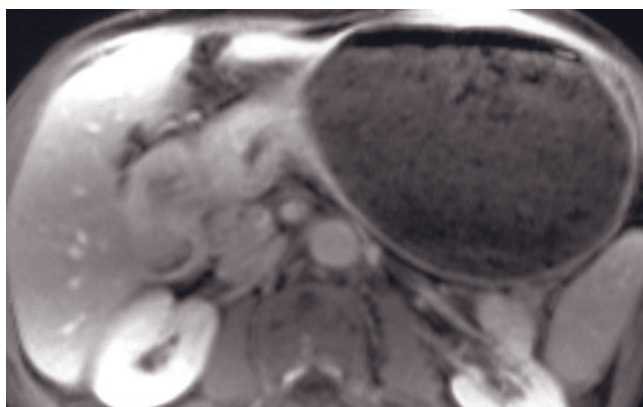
(Continued) heterogeneous enhancement. On 2-min postgadolinium image (d), the tumor continues to enhance but to a lesser extent and heterogeneously compared to the remainder of the gastric wall. Note the intense enhancement of the normal renal cortex, which is greater than the enhancement of gastric wall or tumor. (Reprinted with permission from Marcos HB, Semelka RC: Stomach diseases: MR evaluation using combined T2-weighted single-shot echo train spin-echo and gadolinium-enhanced spoiled gradient-echo sequences. *J Magn Reson Imaging* 10: 950-960, 1999.) Coronal T2-weighted single shot echo train spin echo (e), transverse T1-weighted SGE (f), transverse postgadolinium fat-suppressed hepatic arterial dominant phase (g) and hepatic venous phase (h) 3D-GE images demonstrate a large adenocarcinoma (arrow, e) located in the body of the stomach in another patient. The exophytic tumor shows continuity with the stomach wall, and it displaces the transverse colon along its interface with transverse colon. The tumor is also adjacent to the pancreatic head, which is located posteriorly. The tumor demonstrates low signal on pre-contrast images (e, f). Progressive heterogeneous enhancement of the tumor is detected on postgadolinium images (g, h). Central necrosis is also present. Note that the tumor mimics gastrointestinal stromal tumor.
